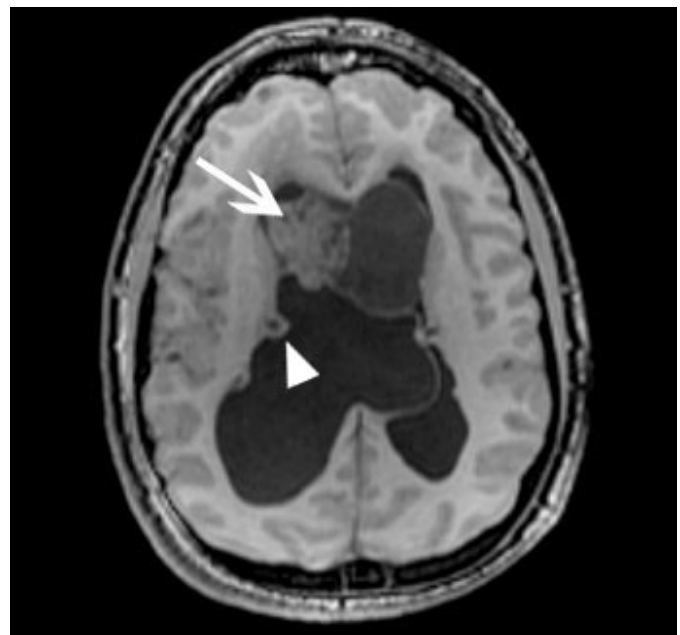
T1-weighted Brain MRI demonstrates multiple subependymal nodules as well as a subependymal giant cell astrocytoma (arrow) at the right foramen of Monro causing hydrocephalus.
